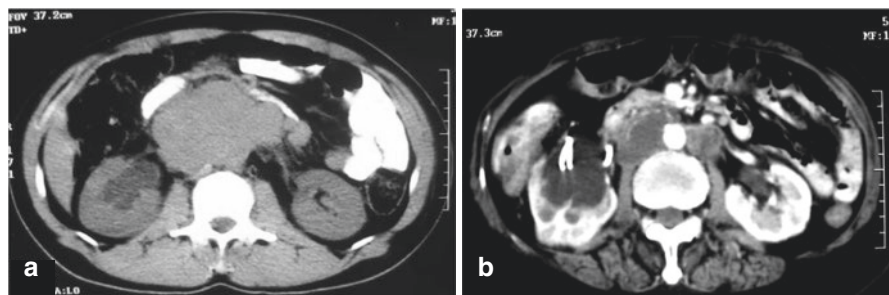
(a) A 32-year-old male patient, complaining of increased abdominal volume and weight loss. Absence of peripheral lymphadenomegaly. Absence of clinical detectable changes in testicular palpation. Ultrasound of testicles and tumor markers was requested as part of the initial investigation, with the finding of a 10 mm nodule in the left testis and a slight increase in HCG- β . Radical orchiectomy was performed, and the pathological analysis showed a pure seminoma. The patient was treated with chemotherapy with complete response, without intervention on the retroperitoneal mass. (b) A 70-year-old female patient complaining of vaginal bleeding and pelvic pain. Vaginal touch showed a tumor on the uterine cervix. Note on CT the presence of secondary retroperitoneal lymphadenomegaly from a primary squamous cell carcinoma of the uterine cervix. Double J catheter was placed on the right kidney due to uretero-hydronephrosis
